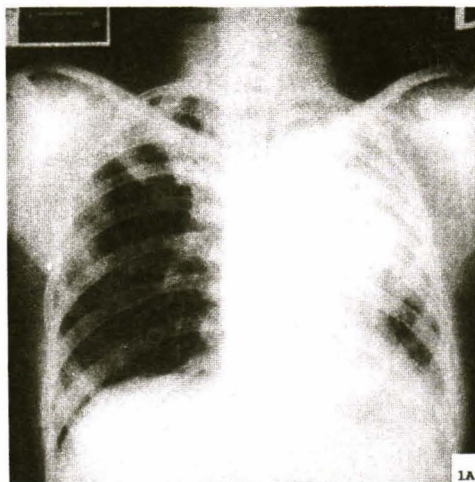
The first chest radiography on admission demonstrated bilateral patchy infiltration, more on left upper lung fields.
